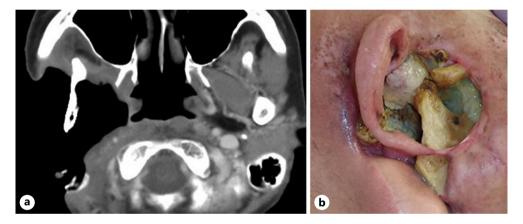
a Computed tomography findings of necrosis of the skull base and the parapharyngeal soft tissues.b Gross appearance of necrosis of the skull base and the parapharyngeal soft tissues.
